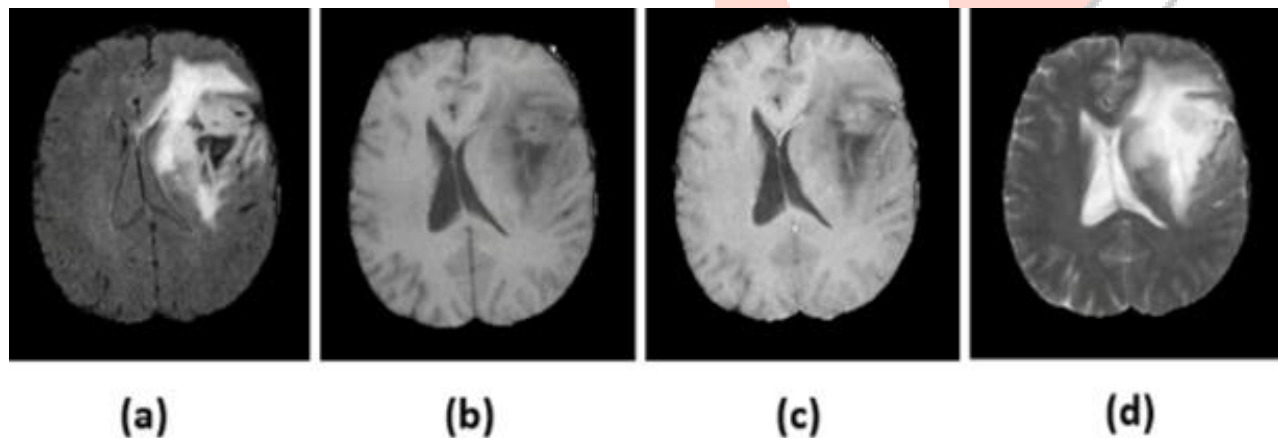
(a) FLAIR (b) T1-w (c) T1-w contrast enhanced (d) T2-w MRI brain Images with LG glioma colle
